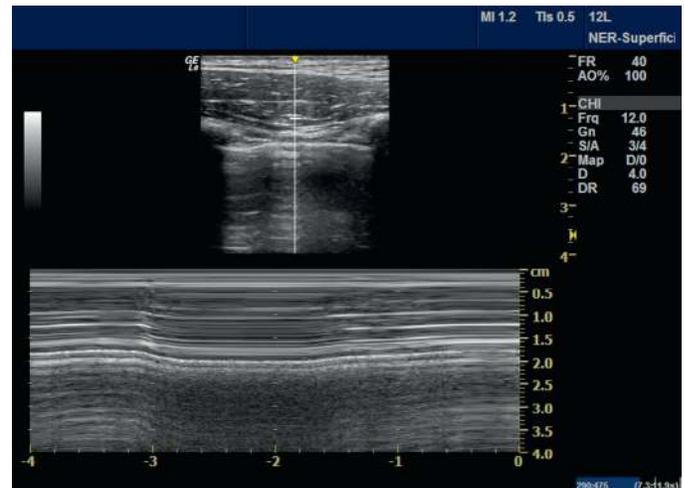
Seashore Sign. M-mode ultrasound of normal lung.
